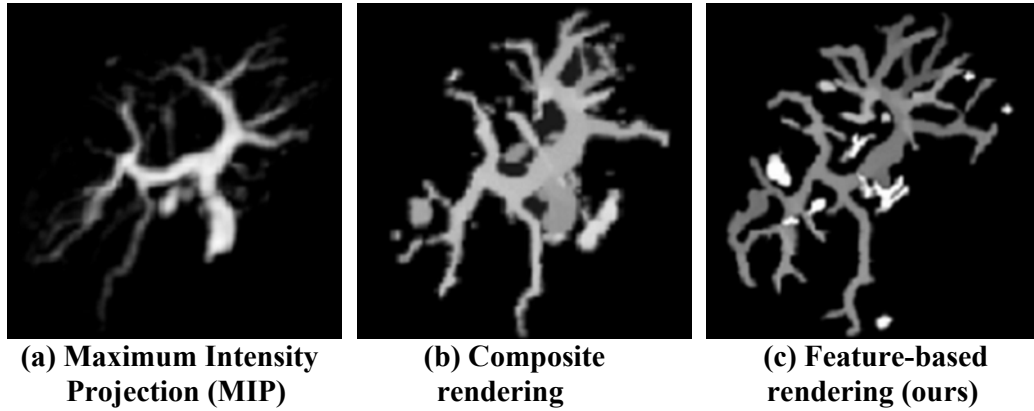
Visualization images obtained by applying three volume rendering methods on the same liver CT dataset. The first two images only show the vessels since the tumors cannot be differentiated from liver tissue based on their intensity values. The third image, produced with our method, shows both the vessels (dark) and the tumors (bright).
